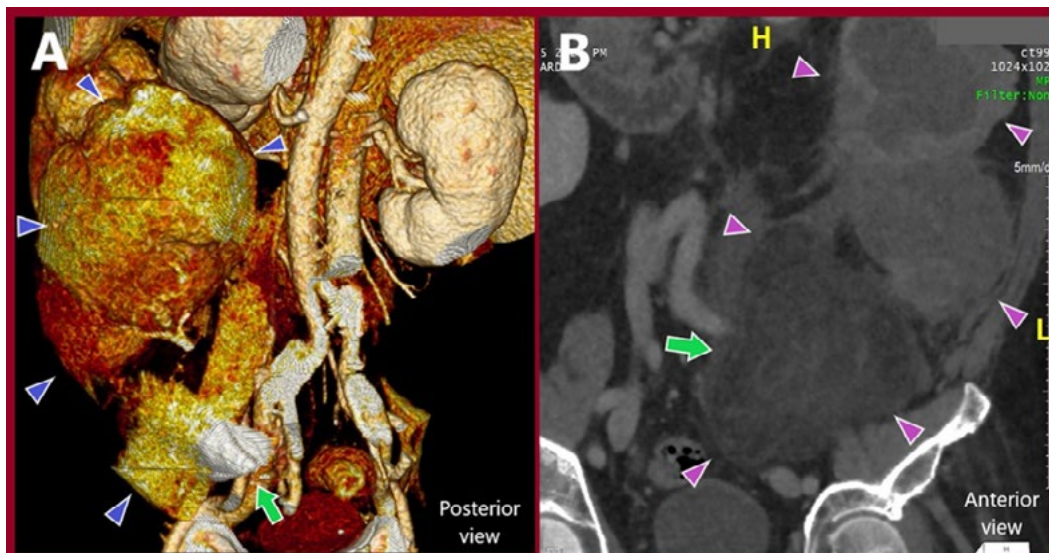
A large retroperitoneal sarcoma (arrowheads) encasing partially the iliac vessels (arrow), A) 3D-Reconstruction and B) Multiplanar Reconstruction of a Computed Tomography Angiography (Coronal view).
